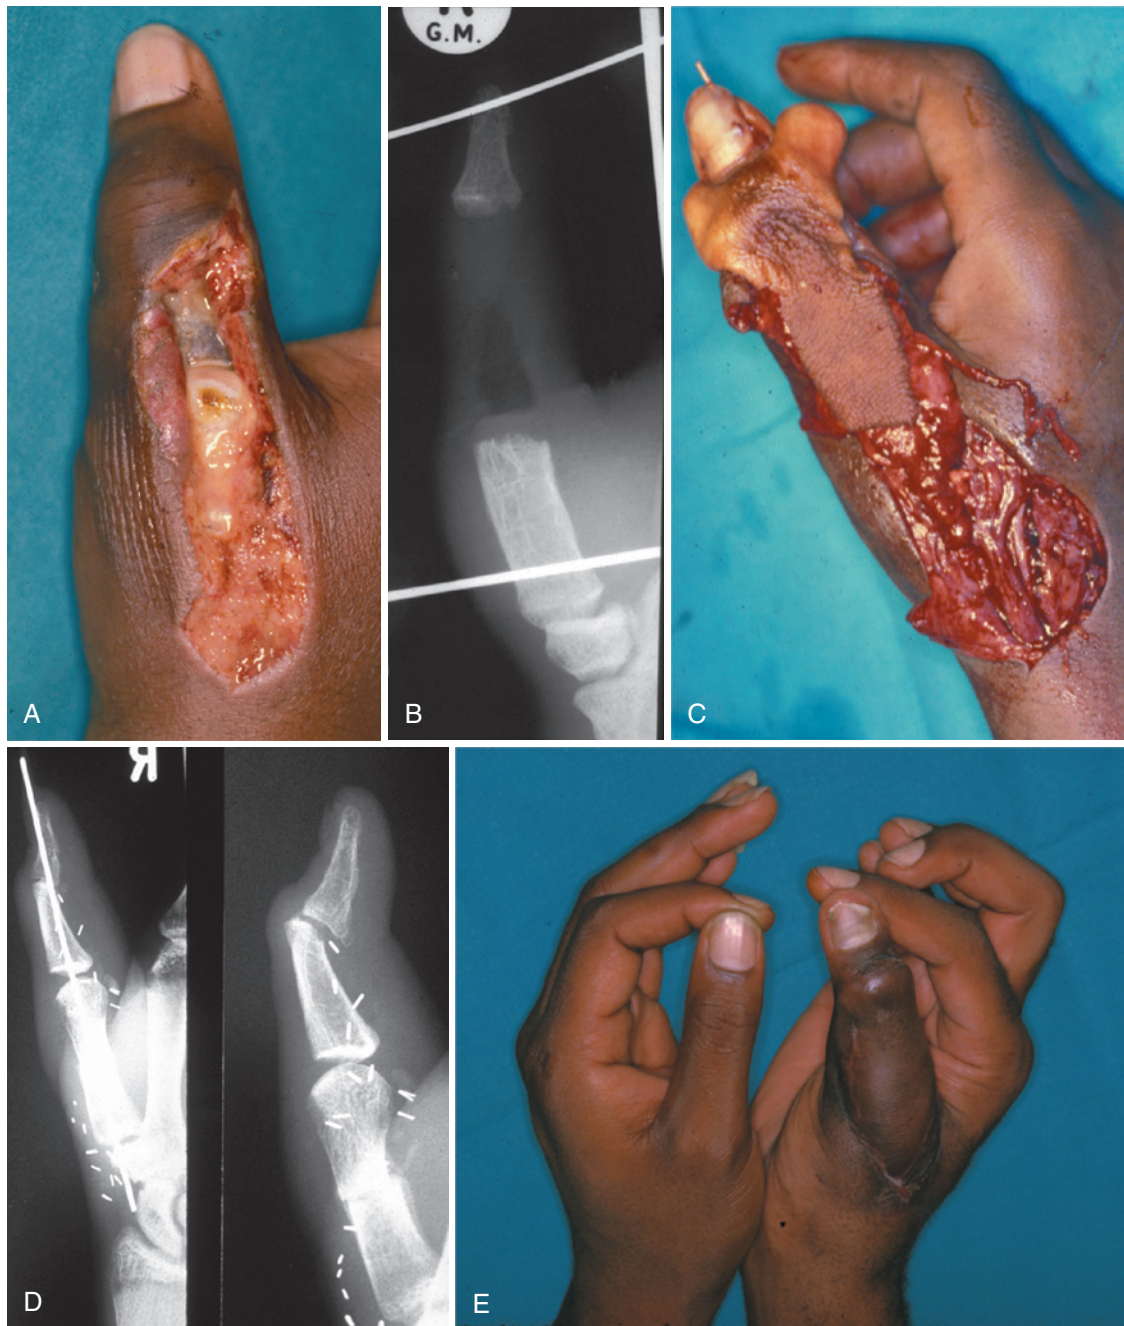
A 27-year-old man sustained a bite injury to his thumb during an assault. He developed a severe infection of the thumb MP joint, with subsequent spread to the metacarpal head and proximal phalanx. The volar soft tissue, flexor tendon, and neurovascular structures were intact. A, Open draining wound with exposed metacarpal head and necrotic proximal phalanx. B, Radiograph taken after resection of all necrotic bone. C, A free vascularized second toe transfer was used to reconstruct the bone defect, extensor pollicis longus tendon, and soft tissue defect. D, Radiographs immediately after surgery with Kirschner wire stabilization and at 1-year follow-up. E, Appearance and function of the reconstructed thumb at 1-year follow-up. There is no evidence of recurrent infection. (Copyright courtesy of Milan Stevanovic and Frances Sharpe.)
